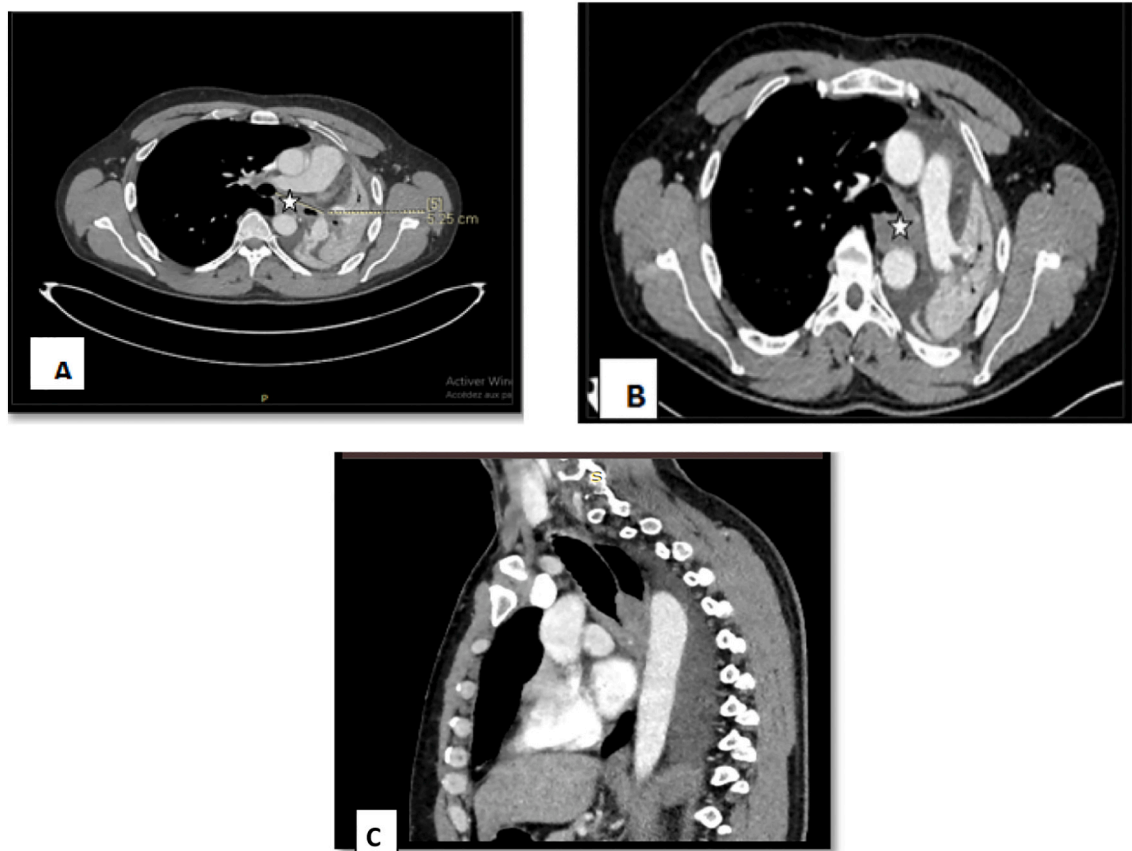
A and B: Injected thoracic CT showing the tumor invading the MLB and extended to the carina, C: Thoracic MRI eliminating esophageal involvement.
